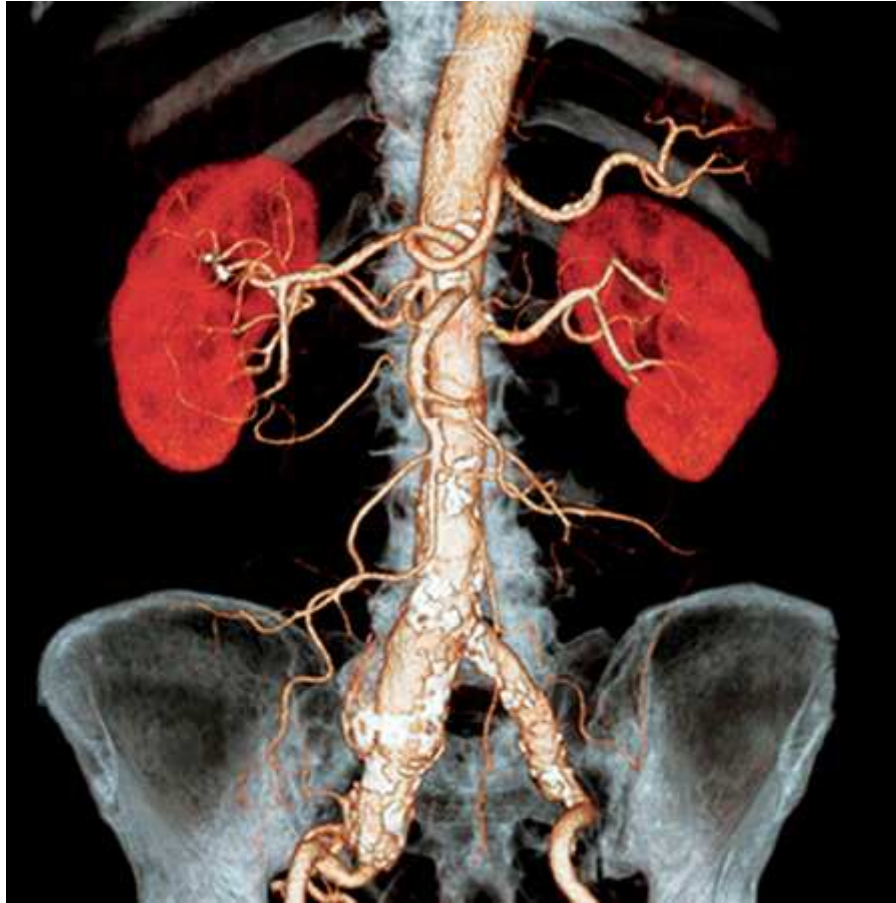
Color CT angiography in three-dimensional format. Courtesy Toshiba America Medical Systems.
